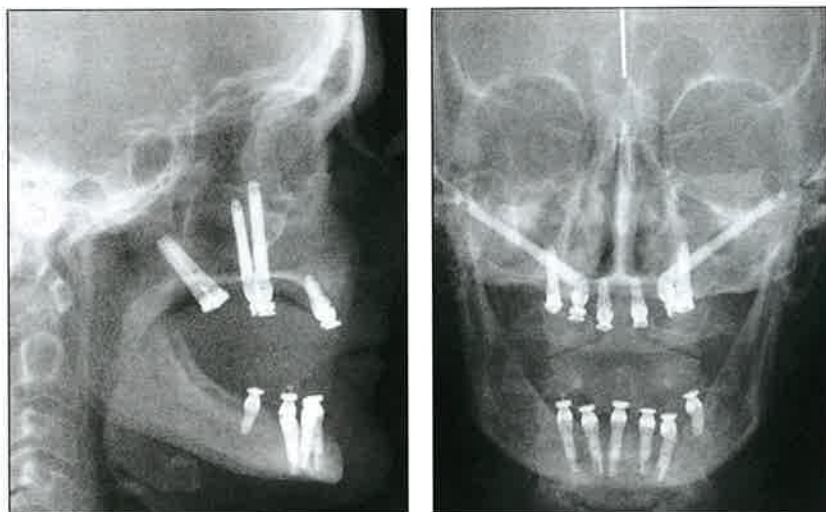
(left) Postoperative lateral cephalometric radiograph obtained following delivery of the provisional acrylic resin prosthesis the day of implant placement.
